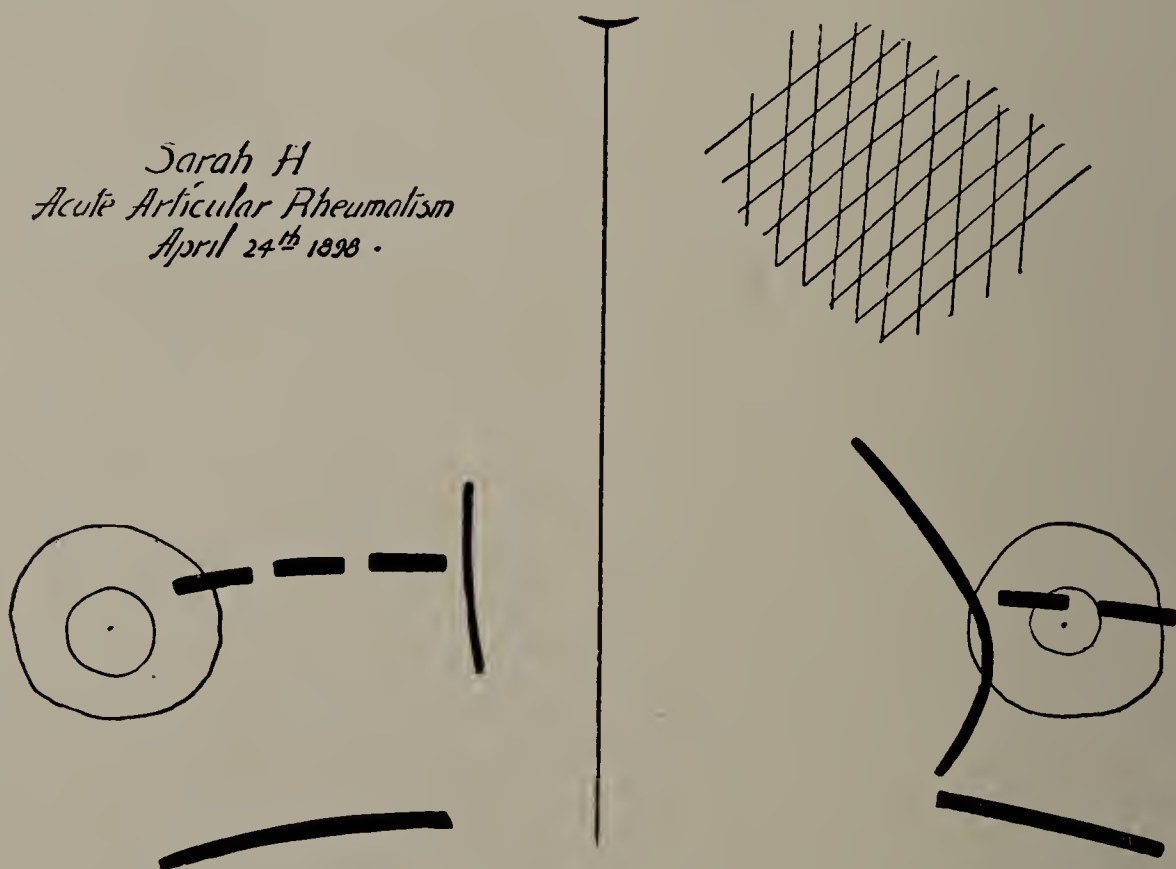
Sarah H. April 24, 1898. X-ray tracing. Left apex darker than normal. Excursion of diaphragm on left side, 5 centimetres; on right side, 6.5 centimetres. (One-third life size.)
